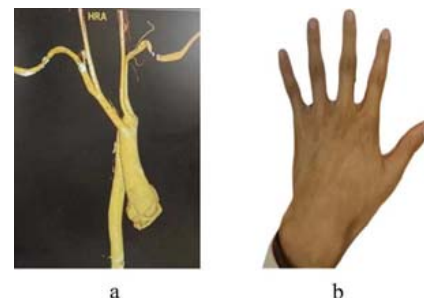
Clinical characteristics of MFS family. (a) Computed tomography scan showed the type A aortic dissection of the proband (32). (b) The proband's old brother (31) exhibited spidery-like fingers
